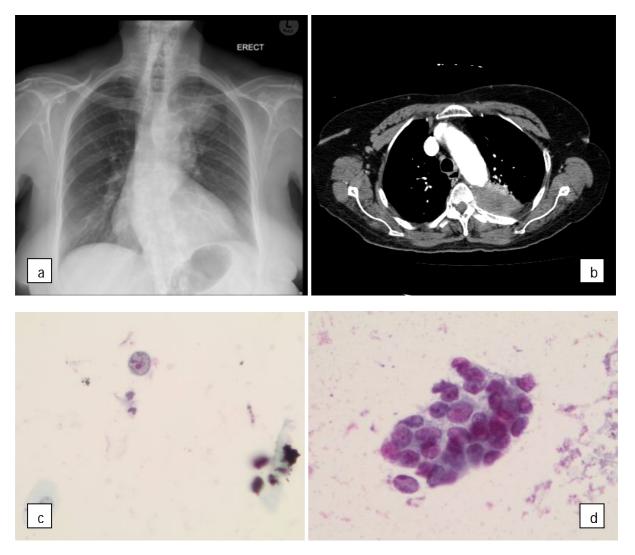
Left upper lobe mass with infiltration of the chest wall and early rib destruction on chest X-ray (a) and CT (b). Sputum - malignant. Sparse cells present with extremely high N/C ratio, chromatin clearing with a thickened, irregular nuclear membrane and prominent nucleolus. These cells were missed with manual screening (c). TTNA - Large cell undifferentiated carcinoma (d).
